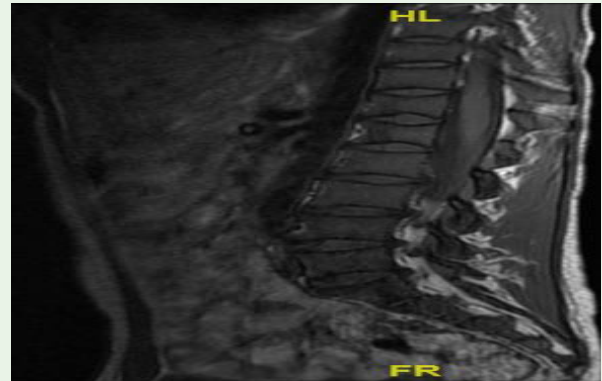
T1W MRI showing marrow infiltration at L5, S1 and S2, and H shaped vertebra.
